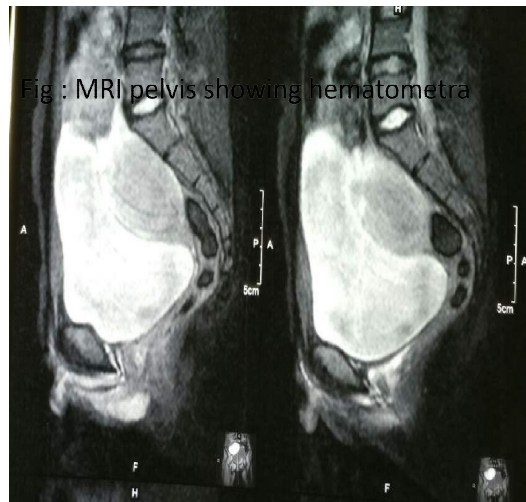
MRI pelvis showing hematometra
